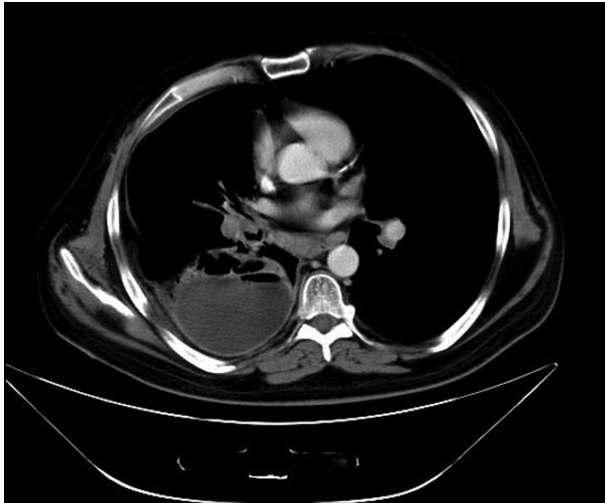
CT image of thoracic cavity lesion of the lower lobe of the right lung (case 11).
